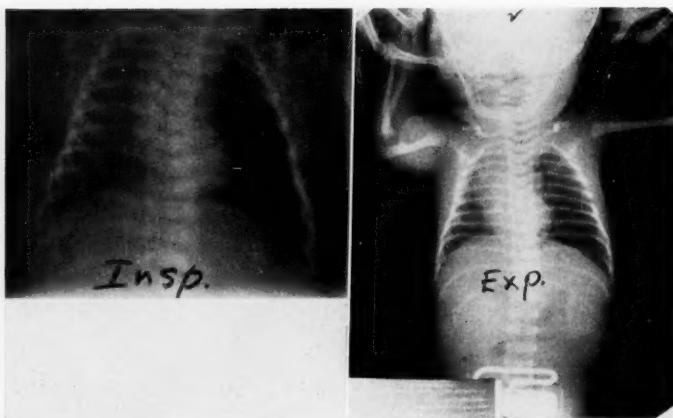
Roentgen film taken approximately 8 hours after full-term normal delivery. There is an expiratory check-valve mechanism with obstruction of the left main bronchus. There had been no immediate respiratory difficulty. Gradual onset of restlessness, and the infant seemed to be struggling to breathe. There was slight cyanosis unrelieved by oxygen. The breath sounds were absent on the left. The condition gradually deteriorated. Tracheobronchial suction 12 hours after birth was productive of thick, tenacious mucus. Fluoroscopy immediately following suction showed a normal chest.
